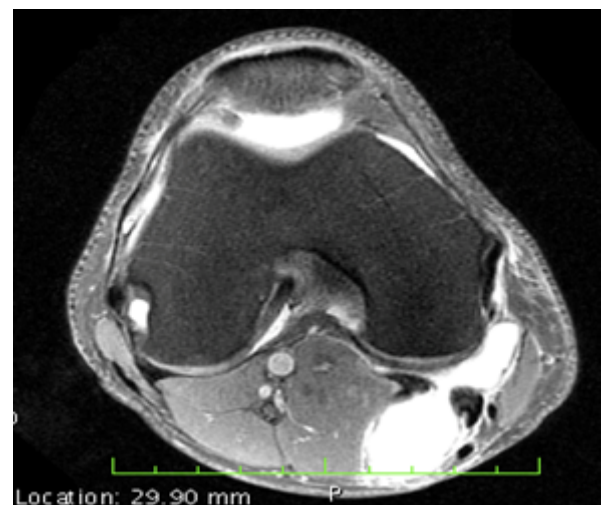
Axial proton density, fat saturated magnetic resonance image of the right knee demonstrating a 3.0 mm and 4.0 mm multiloculated popliteal cyst has developed and is probably leaking fluid superficial to the medial gastrocnemius in the calf.
